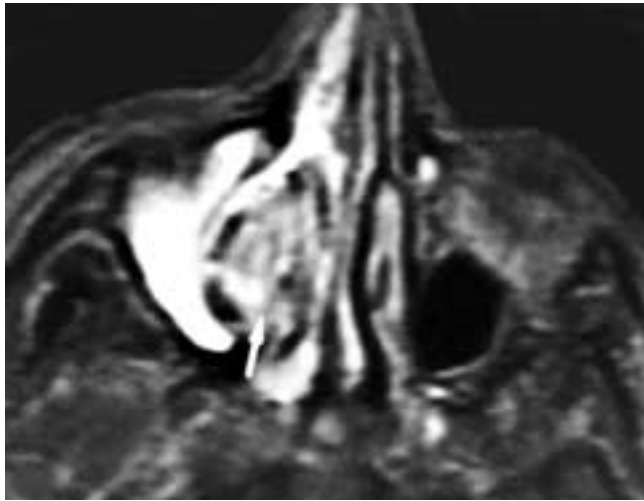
Axial T2-weighted MR image shows an expansile right nasal fossa mass (*arrow*) that obstructs the right antrum. The tumor has a low to intermediate signal intensity, and the obstructed secretions have a high signal intensity. This patient had a melanoma.
